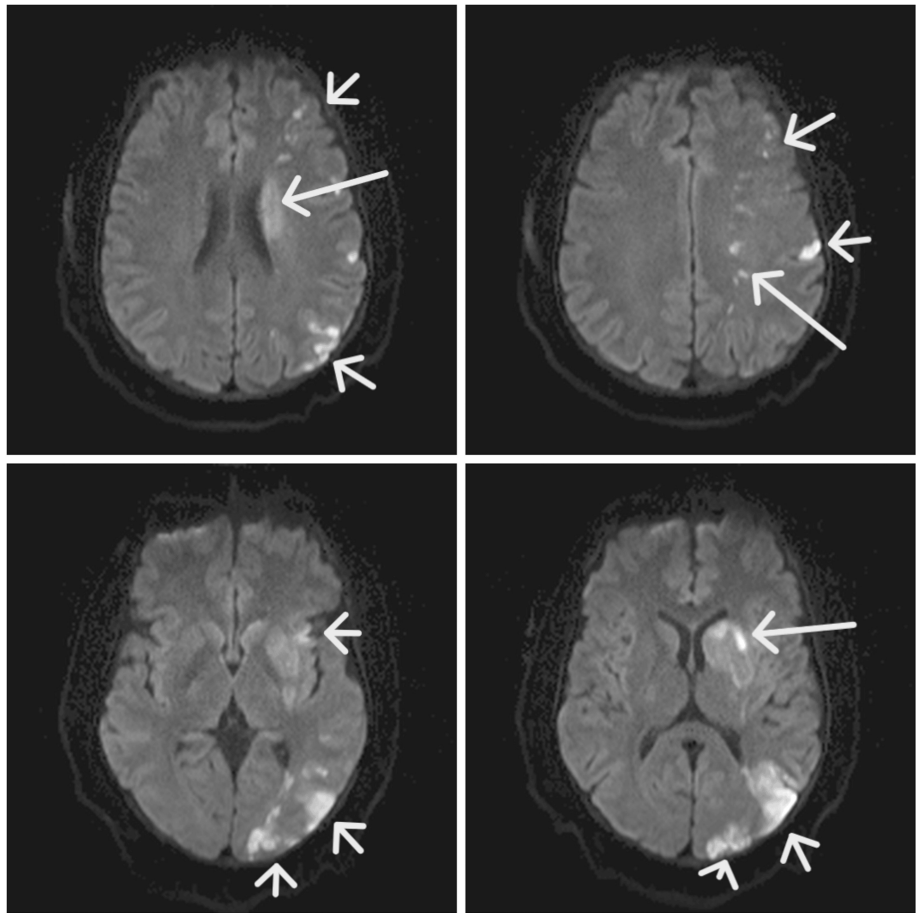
MRI brain DWI showing left MCA territory infarct (see arrows)
